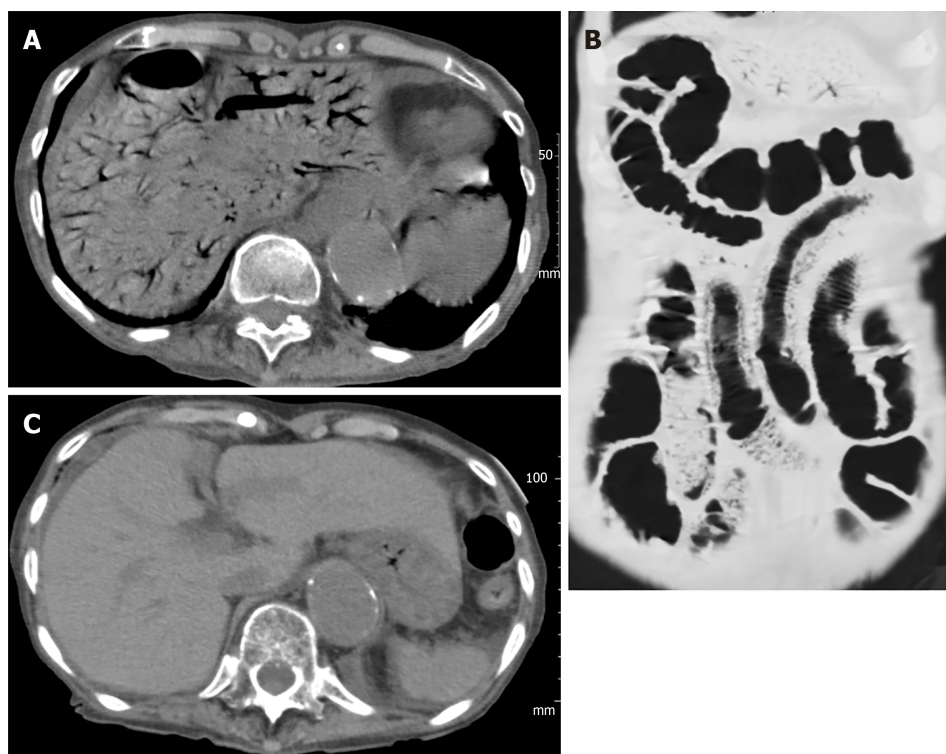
Abdominal computed tomography images of case 2. A: Extensive hepatic portal venous gas; B: Intestinal pneumatosis were found on the first hospital day; C: However, hepatic portal venous gas disappeared on the seventh hospital day.
